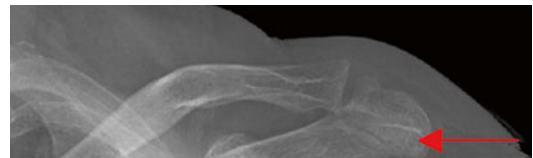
Anteroposterior radiographs of the left shoulder demonstrating Grade 3 stress fracture of the acromion process
